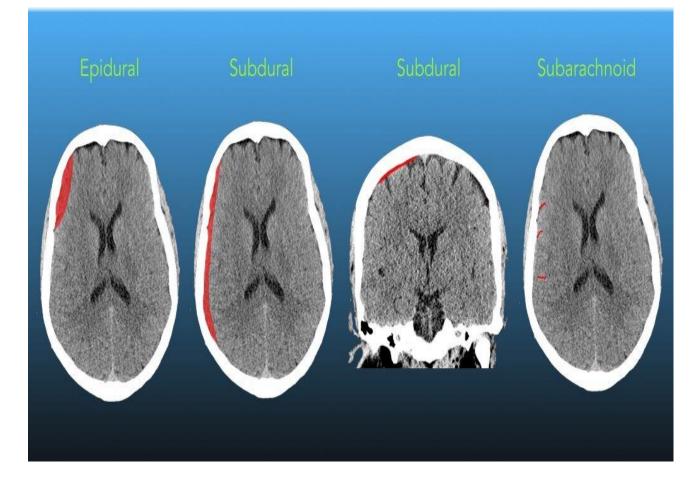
4. CT scan Extra Axial Haemorrhages
